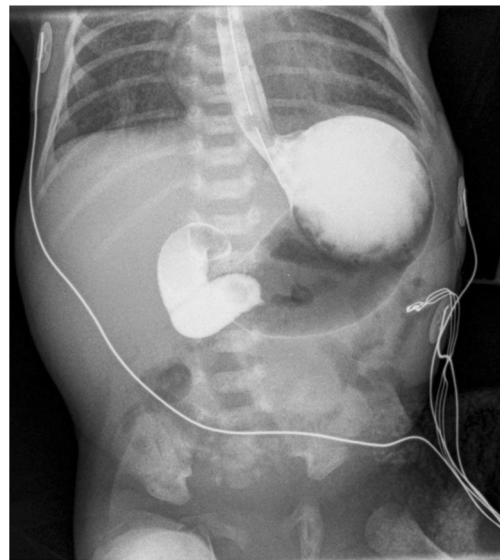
Image in a 7-day-old boy, 29 weeks' gestational age. A 3-min radiograph from a bedside UGI study demonstrates obstruction of the duodenum, which narrows to a beak, consistent with midgut volvulus. The findings were confirmed at surgery
